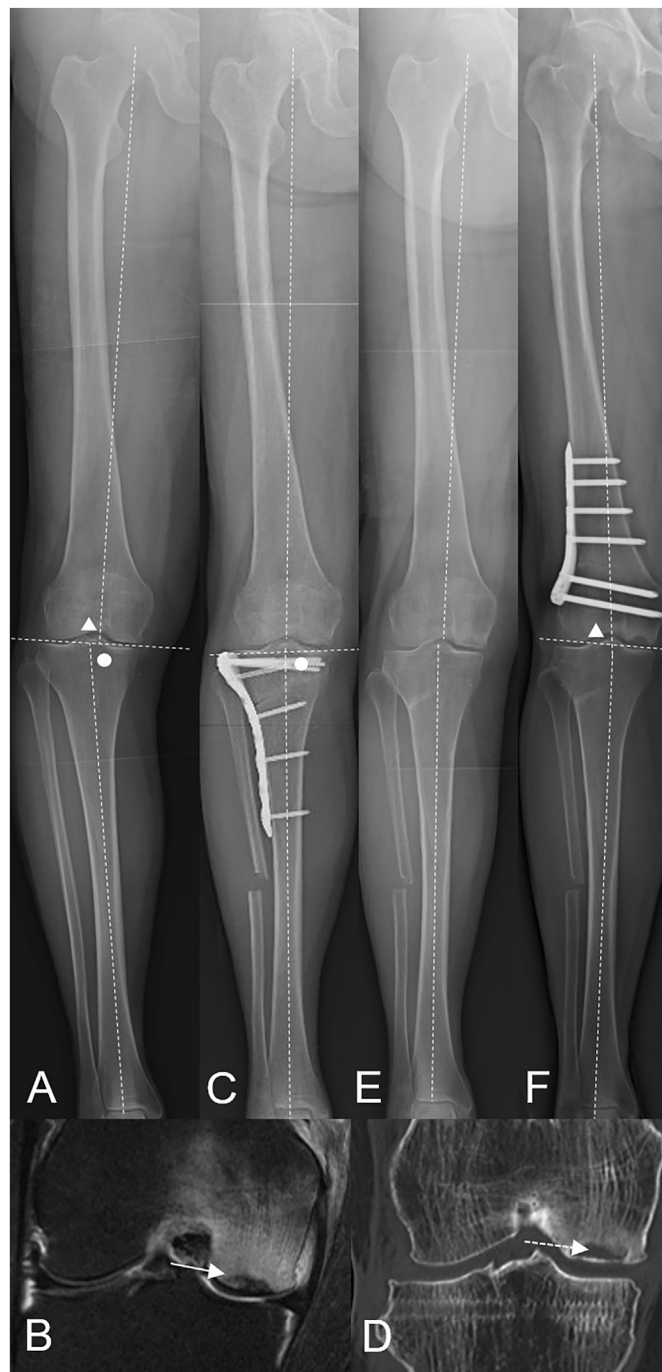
Additional DFO (Case 3 in Table 1). A. Full-length anteroposterior radiograph reveals the varus deformity before primary HTO caused by both the femur (mLDFA of 92° [white triangle]) and the tibia (mMPTA of 82° [white circle]). B. A subchondral insufficiency fracture in the medial femoral condyle (white arrow) is detected on a coronal T2-weighted fat saturation magnetic resonance image with no cartilage defects. C. Leaving a slight varus deformity, the leg alignment is anatomically corrected by closed-wedge HTO (HKA angle of -2° [angle between the two vertical dashed lines] and mMPTA of 92° [white circle]). D. The coronal slice of the multiplanar reconstruction computed tomography image at 6 months reveals collapsed osteonecrosis (white dashed arrow) induced by the subchondral fracture. E. Despite the lack of correction loss (HKA angle of -2°), the necrosis is not improved at 1 year after primary HTO. F. Appropriate alignment is achieved after the additional DFO (HKA angle of 2° and mLDFA of 86° [white triangle]). HTO; high tibial osteotomy; mLDFA, mechanical lateral distal femoral angle; mMPTA, mechanical medial proximal tibial angle; HKA angle, hip-knee-ankle angle; DFO, distal femoral osteotomy.
